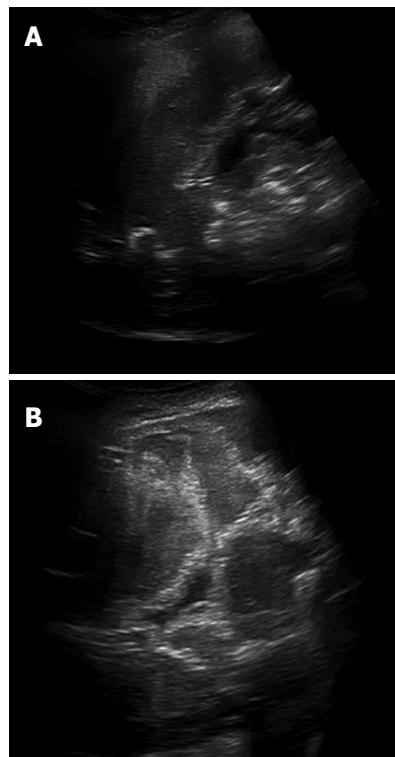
Alveolar echinococcosis in a 41-year-old woman. Abdominal gray-scale ultrasonography (US) image shows a heterogeneous mass lesion in the right lobe of the liver. The mass is generally hypoechoic but contains hyperechoic foci of calcifications (A). Alveolar echinococcosis in a 38 year old woman. Abdominal gray-scale US image shows a heterogeneous, hyperechoic lesion without calcifications (B).
